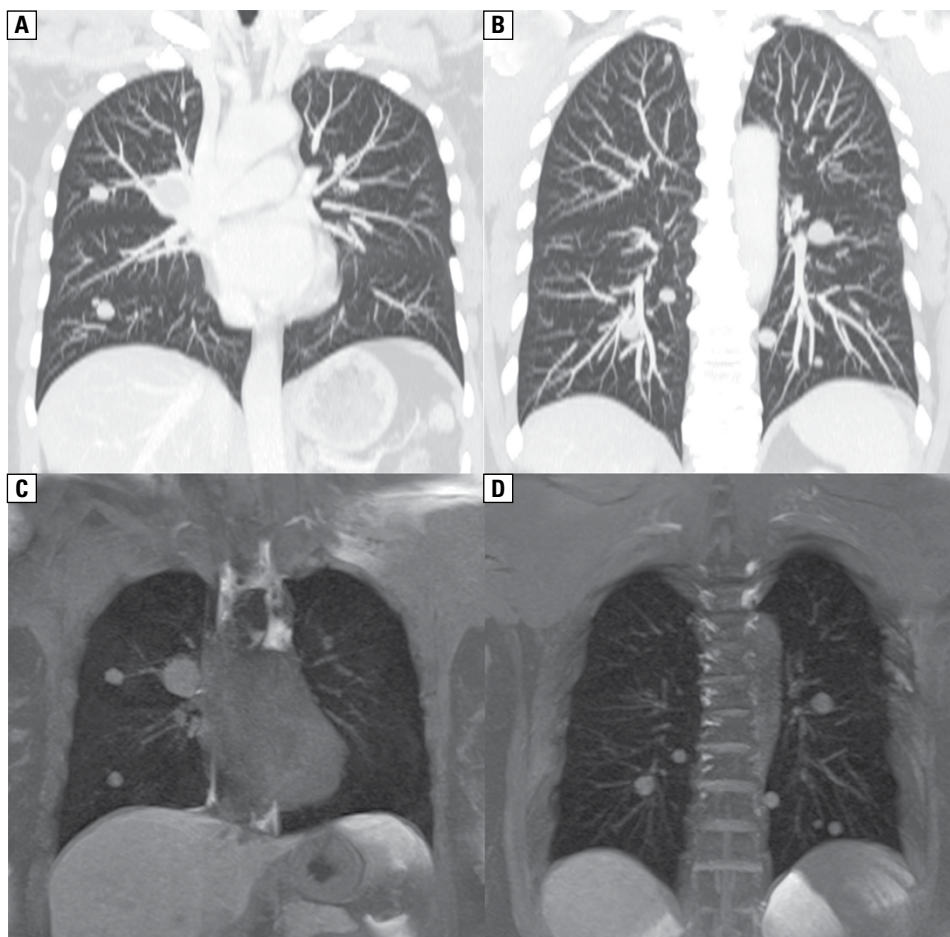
Corresponding sections (coronal plane) of chest computed tomography (A, B) and magnetic resonance (C, D) showing good agreement in the imaging of the pulmonary nodules
